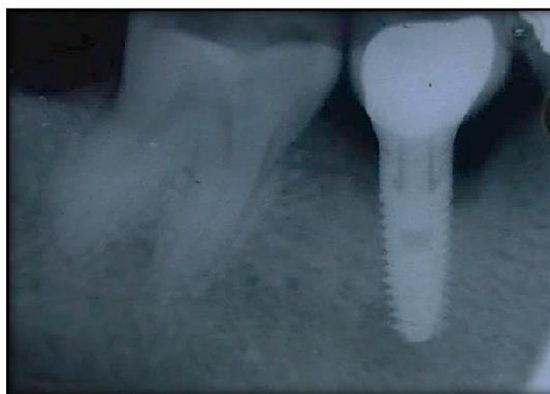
Preoperative radiograph revealing crestal bone loss.
